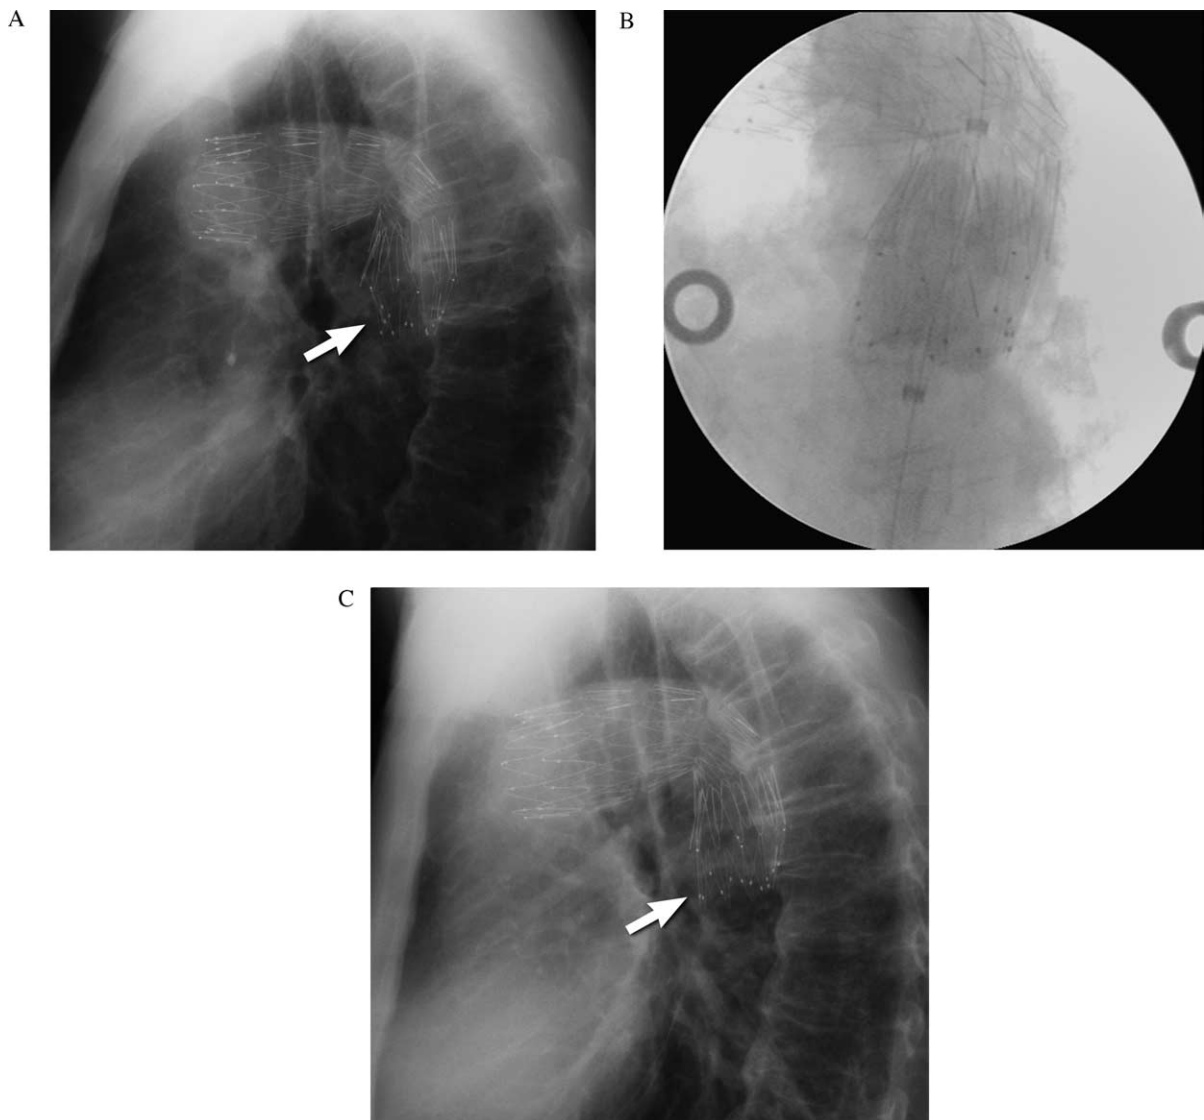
(A) Chest X-ray shows incomplete opening of distal bare stent (Zenith Cook TX1). No endoleak was observed at CT or aortography (not shown). (B) Ballooning of the stent with a trilobated balloon (Gore WL Gore and Ass. Flagstaff AZ). (C) Complete opening of the stent after the procedure.
